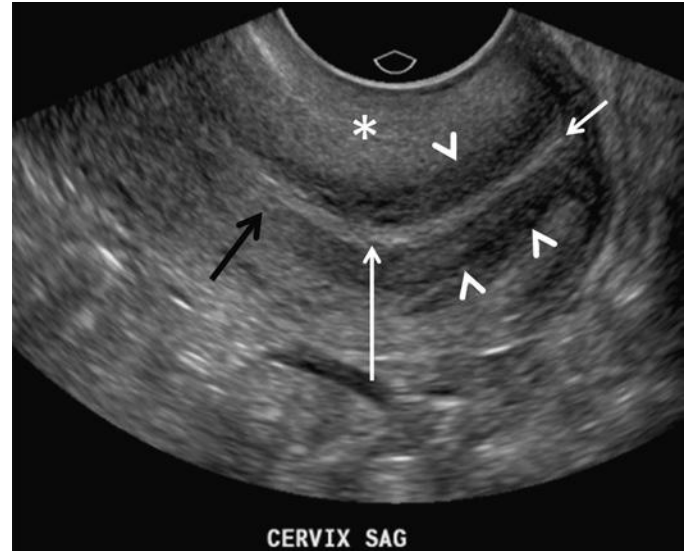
Normal sonographic zonal anatomy of the cervix. Note central linear echogenic endocervical canal (*long white arrow*), subadjacent hypoechoic fibrous cervical stroma (*arrowheads*), outer muscular layer of intermediate echogenicity (*asterisk*), external os (*short white arrow*) between the lips of the cervix, and internal os (*black arrow*) at the level of narrowing or constriction between the body of the uterus and the cervix.
